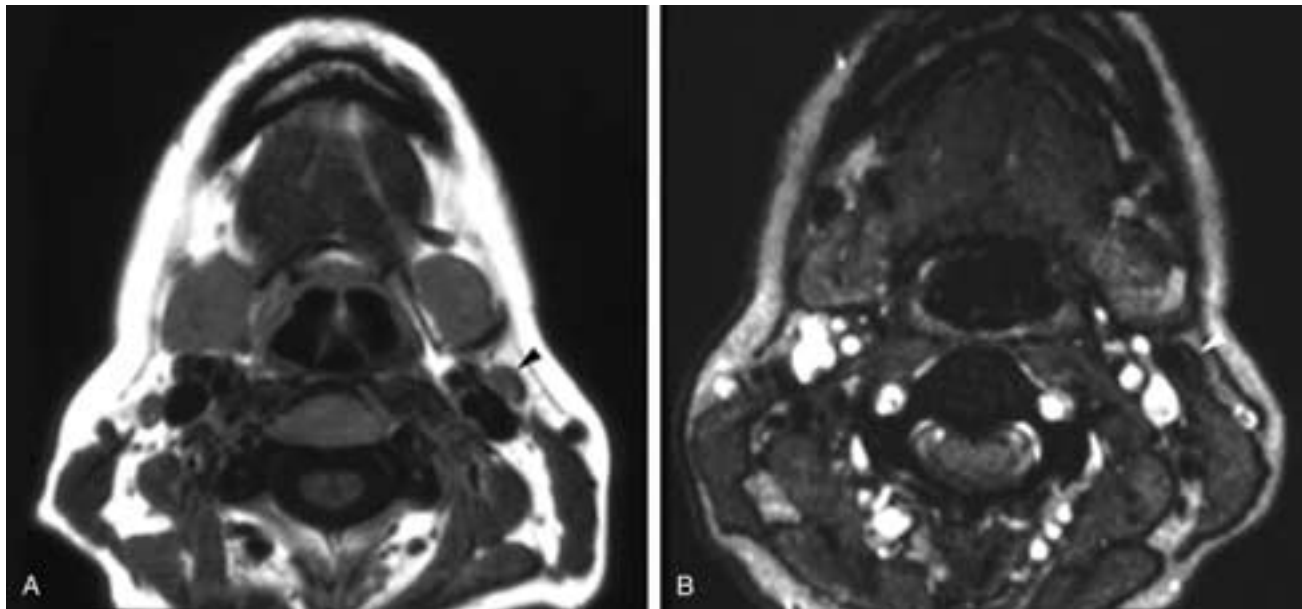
Axial T1-weighted MR image (A) shows a small left level II homogeneous node (arrowhead). Axial gradient echo MR image (B) taken 24 hours after A and the injection of 2.6 mg/kg Combidex, a superparamagnetic iron oxide chelated dextran. The level II node in A now has a very low signal intensity (arrowhead) due to the uptake of Combidex. This was a reactive node. (Courtesy of Dr. C. Douglas Phillips.)
